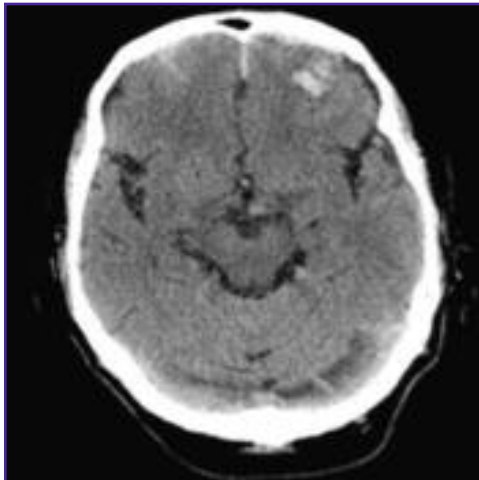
CT scan of head showing very small hyperdense lesions involving both frontal lobes with parafalcine subdural hematoma and minor subarachnoid haemorrhage.
